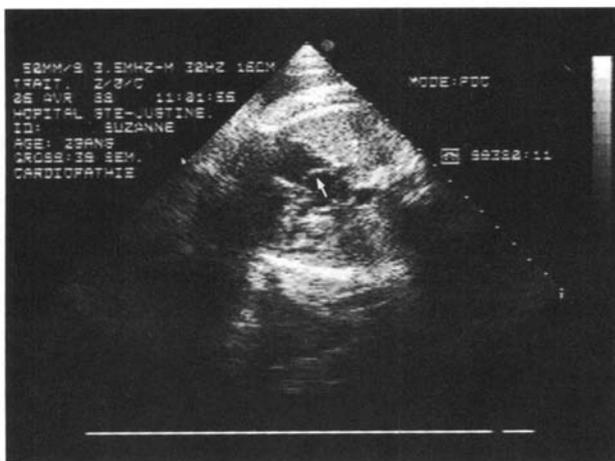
Real-time echocardiographic imaging of the interatrial septum and the flap valve of the oval foramen of a fetus with left ventricular fibroelastosis. An abnormal bulging of the septum towards the right atrium is observed (arrow).
